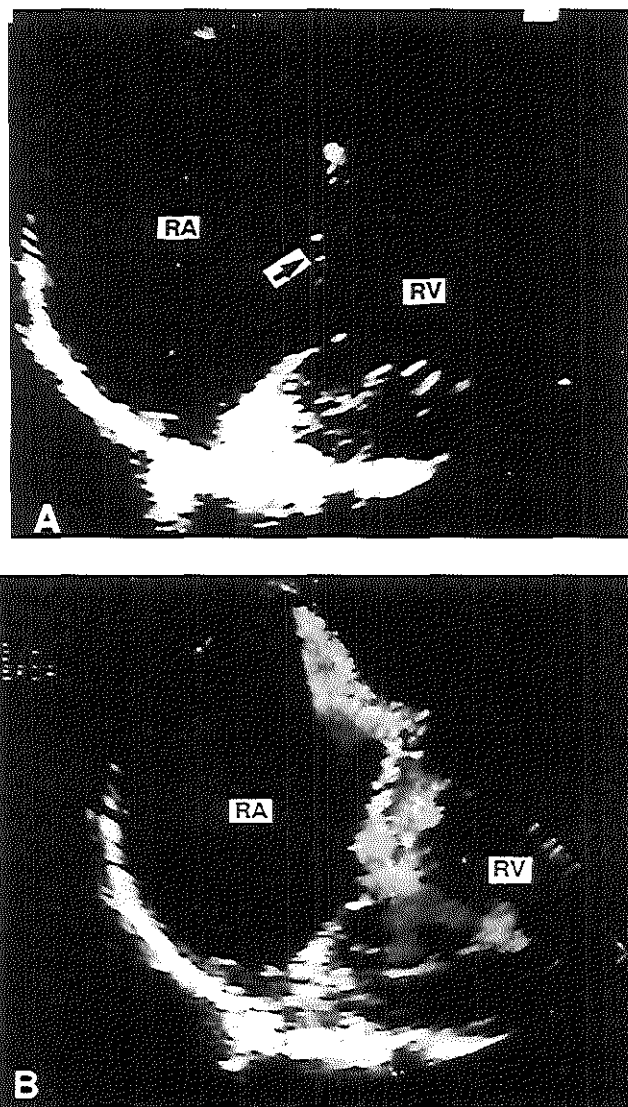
Case 4. A. Transoesophageal study after balloon pulmonary valvuloplasty, demonstrating partial chordal rupture of the anterior leaflet of the tricuspid valve (arrow) with prolapse into the right atrium (RA). B. The colour flow mapping study reveals a moderate tricuspid valve regurgitant jet adherent to the atrial septum.
